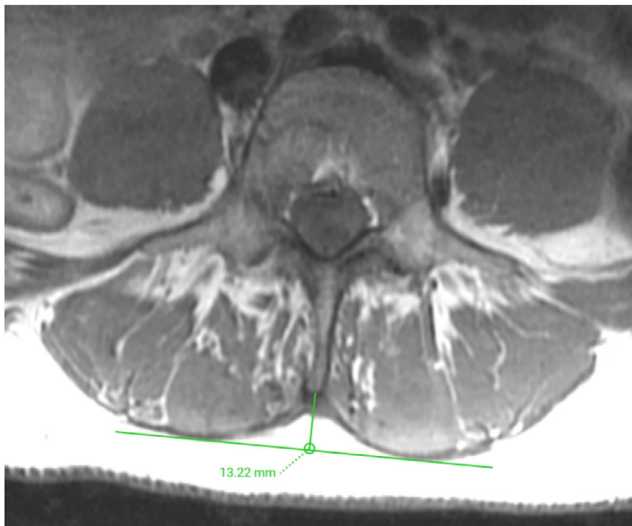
Determination of the lumbar indentation value (LIV). Representative axial T1-weighted fast spin-echo (FSE) image demonstrating the measurement of the LIV at the level of L3/L4, which amounted to 13.22 mm. The LIV is measured as the distance equal to the length of the bulge of the muscle to the attachment of the spinous process.
